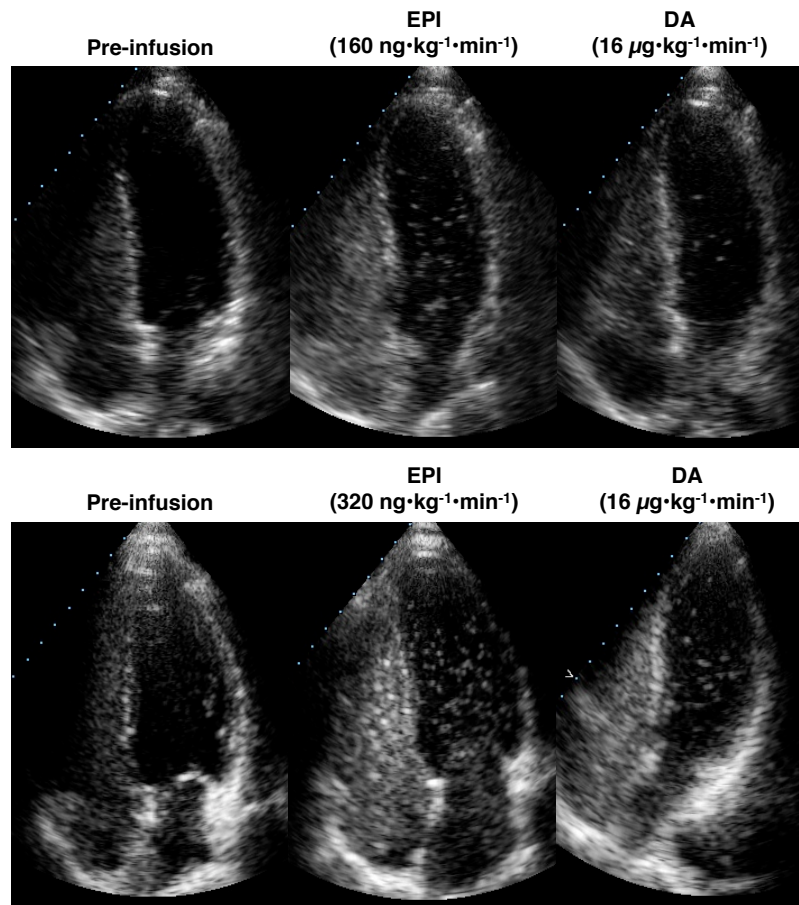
Representative Echocardiograms. *Upper row.* One subject breathing room air at rest (A) before EPI or DA infusion, score=0; (B) during EPI infusion ($160 \text{ ng}\cdot\text{kg}^{-1}\cdot\text{min}^{-1}$), score=3; and (C) during DA infusion ($16 \text{ }\mu\text{g}\cdot\text{kg}^{-1}\cdot\text{min}^{-1}$), score=2. *Bottom row.* A different subject breathing room air at rest (D) before EPI or DA infusion, score=0; (E) during EPI infusion ($160 \text{ ng}\cdot\text{kg}^{-1}\cdot\text{min}^{-1}$), score=3; and (F) during DA infusion ($16 \text{ }\mu\text{g}\cdot\text{kg}^{-1}\cdot\text{min}^{-1}$), score=2.
